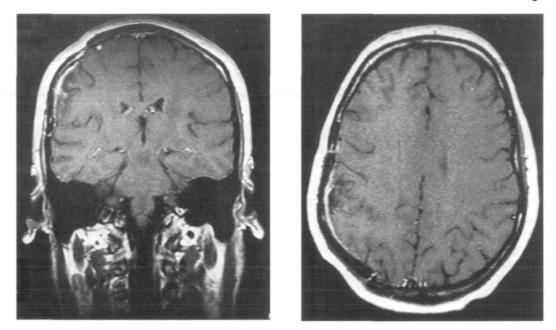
Delayed postoperative contrast-enhanced T1-weighted MRI of the head of Patient H. K. showing the right parietal cortical lesion in coronal (*left*) and transversal (*right*) projection. Courtesy of Professor Felix, Dept of Radiology, Virchow-Klinikum, Humboldt-Universität, Berlin.
